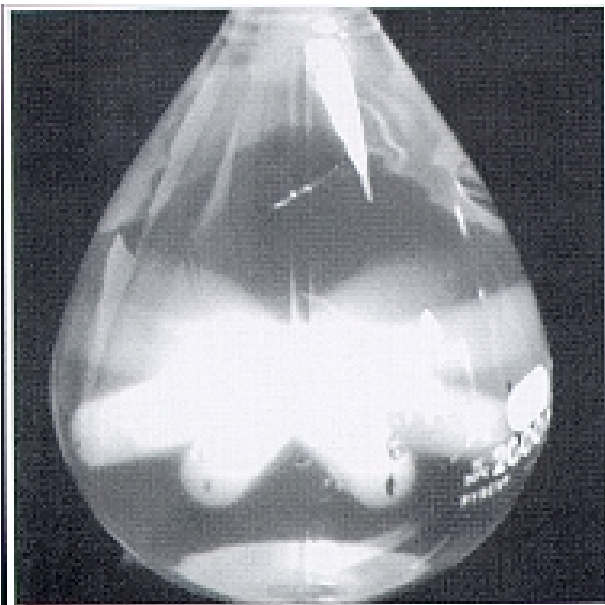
3D dose patterns captured “in a bottle” using polyacrylamide BANGTM gels. The gels turn from transparent to a milky white with radiation exposure. The photograph shows a “cross-firing” pattern of several small intersecting beams. Quantitative cross-sectional images can be read-out by MRI or optical CT scans. Photo courtesy of MGS Incorporated.
